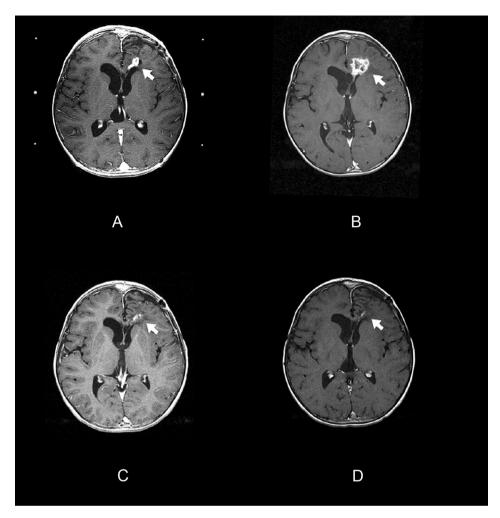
Postcontrast T1-weighted images of a 6-year-old boy on the day of gamma knife radiosurgery and at 6 months, 9 months, and 15 months after gamma knife radiosurgery. (A) On the date of radiosurgery, there was a small enhancing recurrent tumor in the left frontal near frontal horn (arrow). (B) Six months after radiosurgery, there was an increasing enhancing area with a central loss-enhancement portion of the treated tumor (arrow). (C) Nine months after radiosurgery, the enhancing area shrunk without additional treatment (arrow). (D) Fifteen months after radiosurgery, the enhancing lesion further decreased and was not easily observed in magnetic resonance imaging (arrow).
